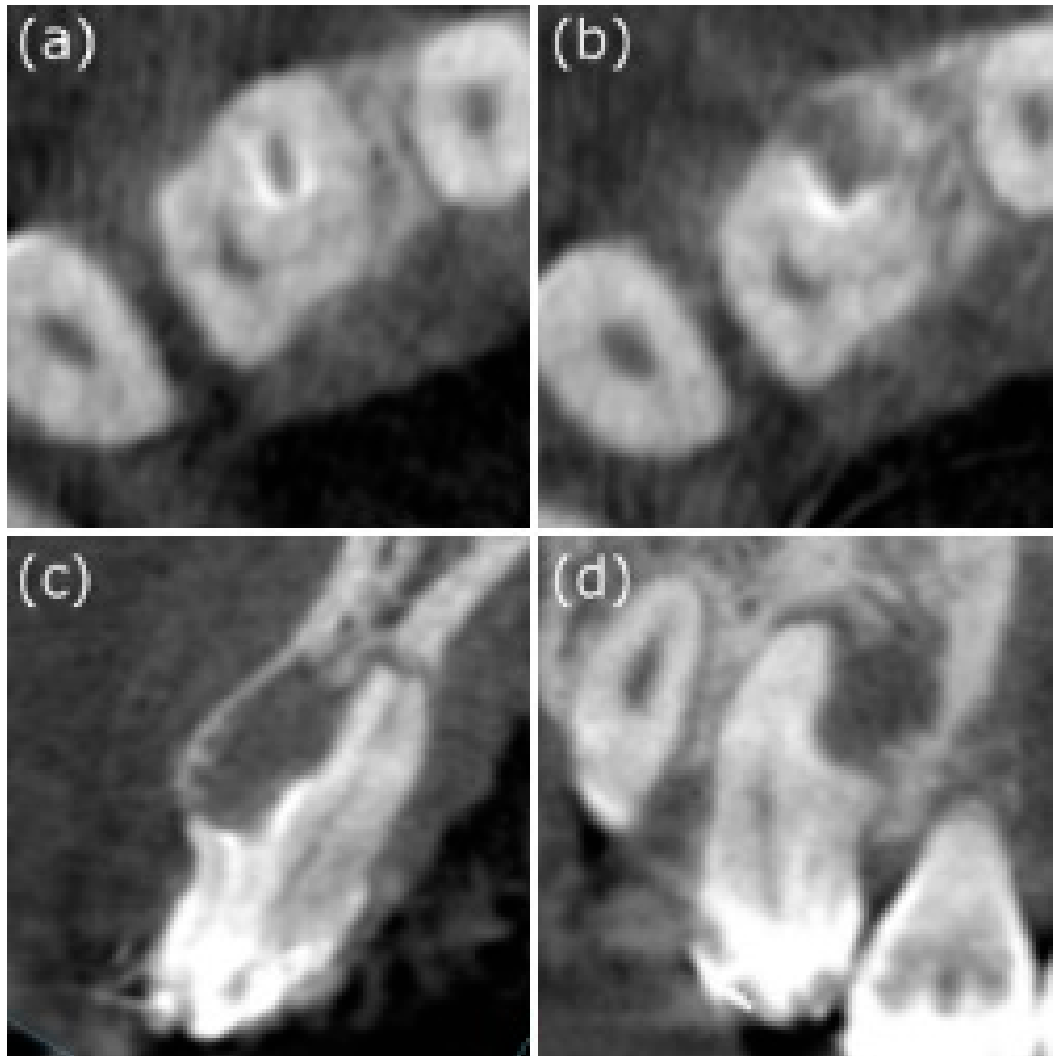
Different sections in cone-beam computed tomography. (a) From the axial view, “pseudo-canal” can be observed on the mesial side, surrounded by the enamel. (b) The opening of the invagination near CEJ can be seen in the “pseudo-canal”, in the middle-third of the root. (c) From the CBCT coronal view, we can observe that the pseudo canal was located near the core part. (d) The CBCT sagittal view showing that the buccal side of the pseudo canal with the opening of the invagination near the cemento-enamel junction, and it was adjacent with a well-defined unilocular peri-invagination radiolucent lesion with a size of 8 mm × 9 mm × 12 mm.
